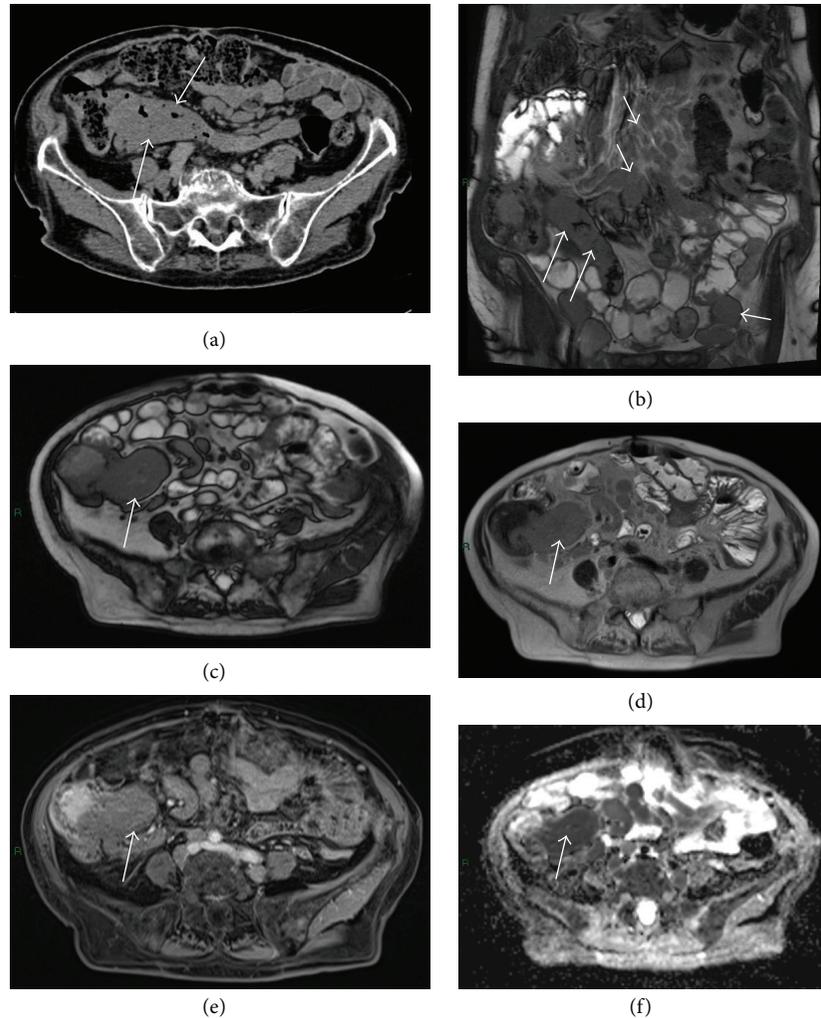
CT and MR enterography in a 68-year-old patient with ileal lymphoma. Axial CT image (a) shows abnormal thickening of terminal ileum (arrows), with aneurysmal pseudo-dilatation. Coronal true fast spin echo (b) shows abnormal thickening of terminal ileum (arrows) multiple mesenteric lymph nodes (short arrows). Axial true fast spin echo (c) and Haste sequence (d) show a long segment of terminal ileum with abnormal thickening, smooth margins, and luminal narrowing with loss of normal mucosal folds (arrows). Axial contrast T1-LAVA (e) sequence shows minimal enhancement of the mass (arrow) infiltrating the small bowel loop, with restriction of the diffusion (ADC) (f) indicative of high cellularity tissue. The morphologic and functional data are suggestive of small bowel lymphoma.
